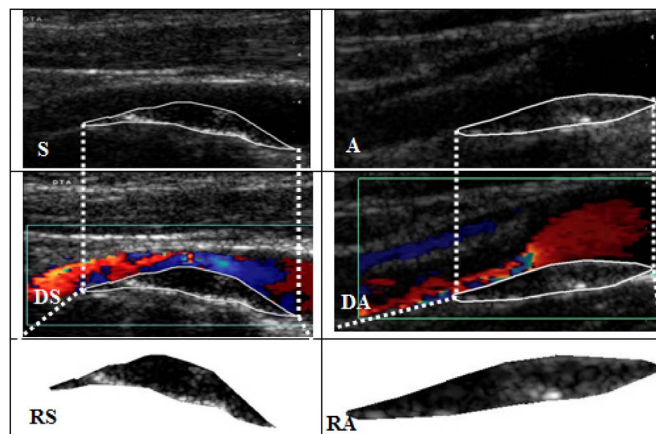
Carotid (S) symptomatic and (A) asymptomatic plaque images. (DS and DA) Corresponding color Doppler images. (RS and RA) Corresponding extracted plaque region of interests (zoomed).
